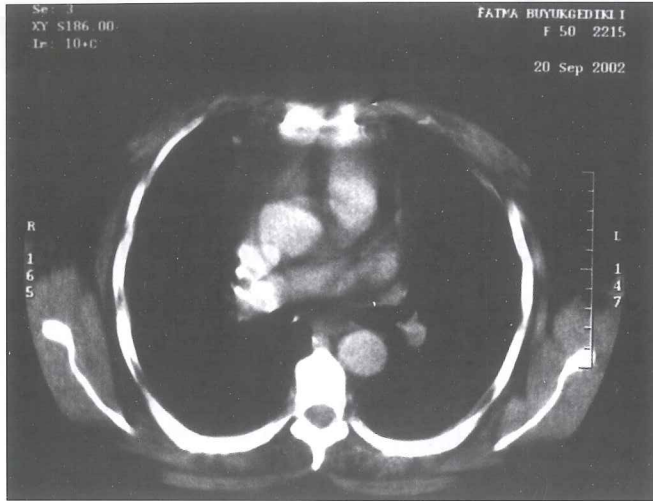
Preoperative CT scan demonstrating the cystic lesion in the right anterior mediastinal region.
